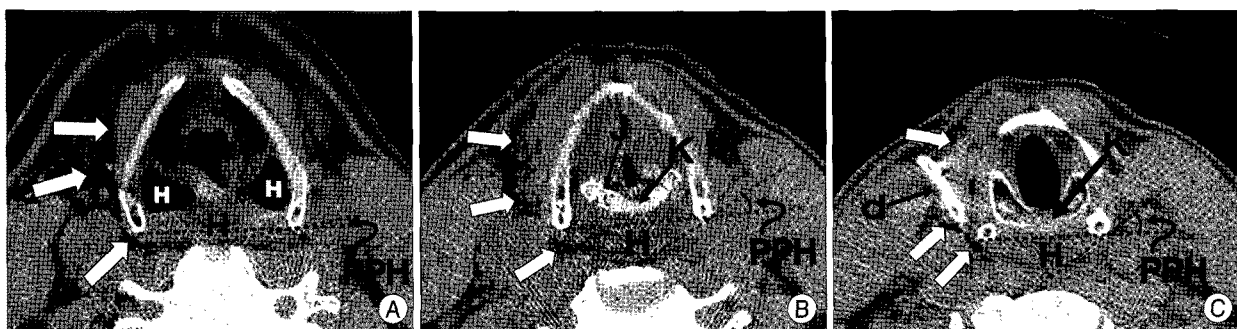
The visceral component bordered by air densities (white arrows) and a drain tube (d) on post-operative neck CT images. The amount of PPH of the hypopharynx (H) increases in caudal direction. A : A scan at the level of SBTC. Air densities in the hypopharynx are observed. B : At the level of the cricoarytenoid joint (J), the amount of PPH is larger. The hypopharynx (H) is located behind the cricoid cartilage (K). C : At the TIHTC, the amount of PPH is largest. No air density is observed in the hypopharynx.
